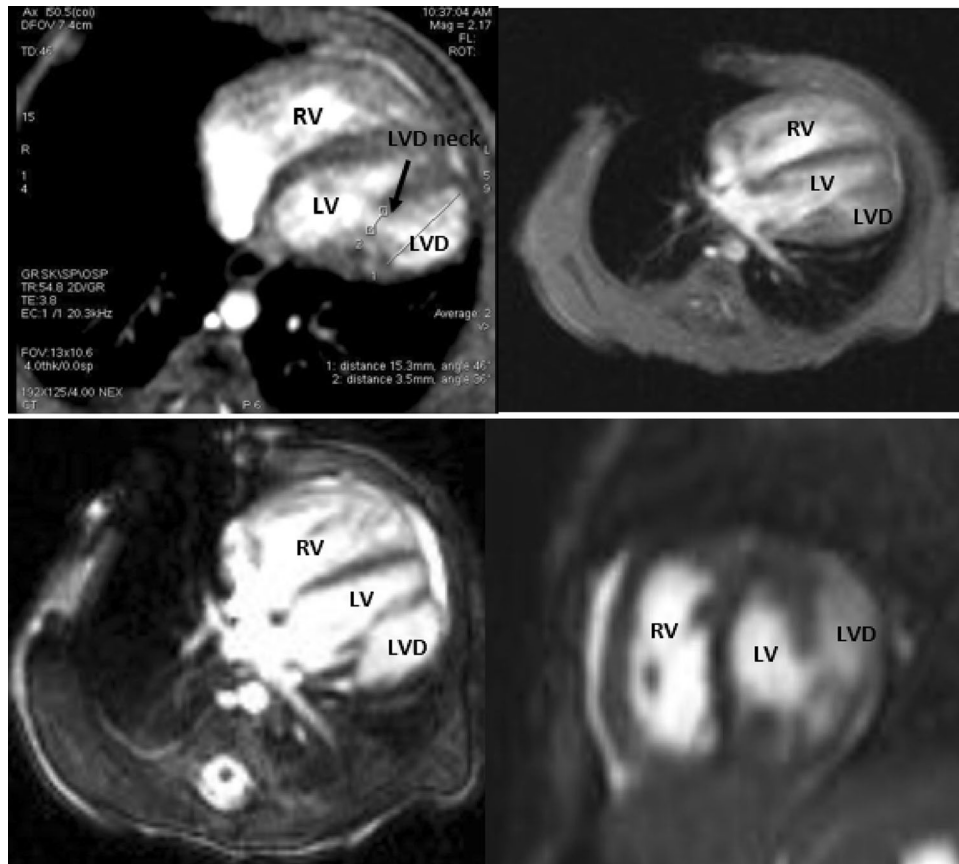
Post-natal cardiac MRI and viability study showed: Large left ventricular diverticulum arises approximately from the mid lateral wall and measures around 5 mm in length, maximum length
